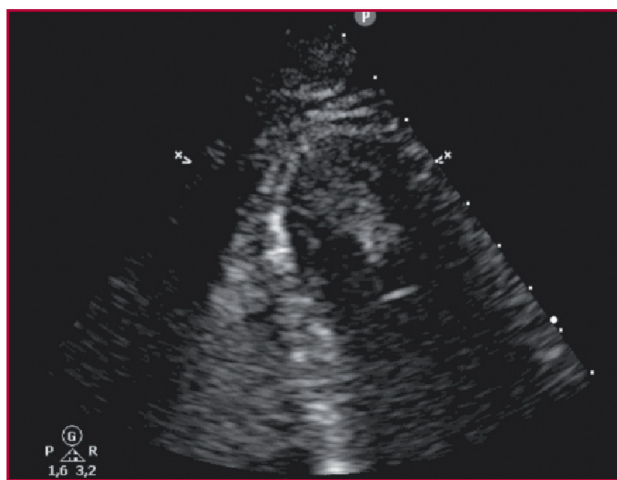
Transthoracic echocardiography (zoom image from the apical 4-chamber view) showing left ventricular thrombus in the apical region
